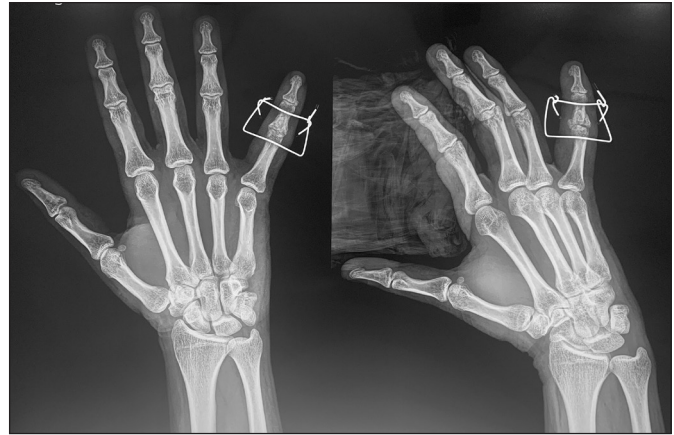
Immediate post-operative X-ray in AP and Oblique views
